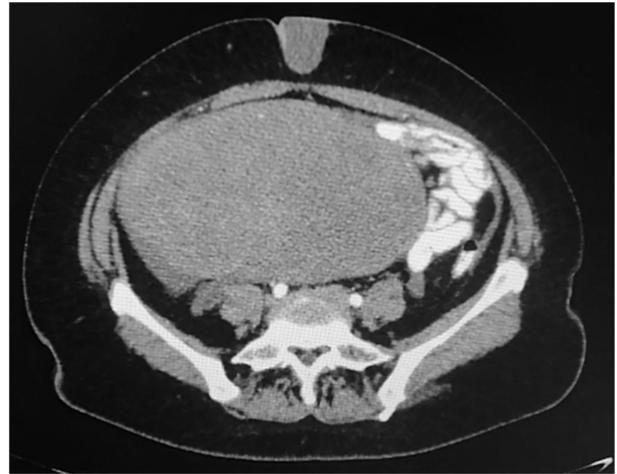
Abdominal CT scan showing a right ovarian mass.
